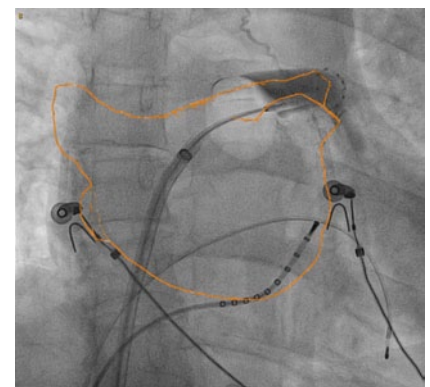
▲ Three-dimensional reconstruction of left atrium, left atrial appendage, and pulmonary vein based on intraprocedural rotational angiography and overlaid on an X-ray real-time fluoroscopic screen. The pulmonary vein angiogram shows good contact between the cryoballoon and left superior pulmonary vein
